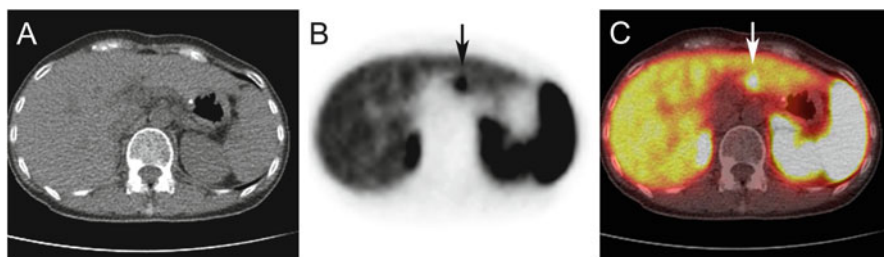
A 51-year-old woman with suspected recurrent gastrinoma. Axial CT (a), DOTATOC PET (b), and fused (c) images are shown. A duodenal gastrinoma was removed by surgery, but recurrence was suspected because of rising serum gastrin levels. Intense focal uptake around the lateral segment of the liver is apparent on the DOTATOC PET and fused images (arrows). A lymph node metastasis was confirmed by surgery
